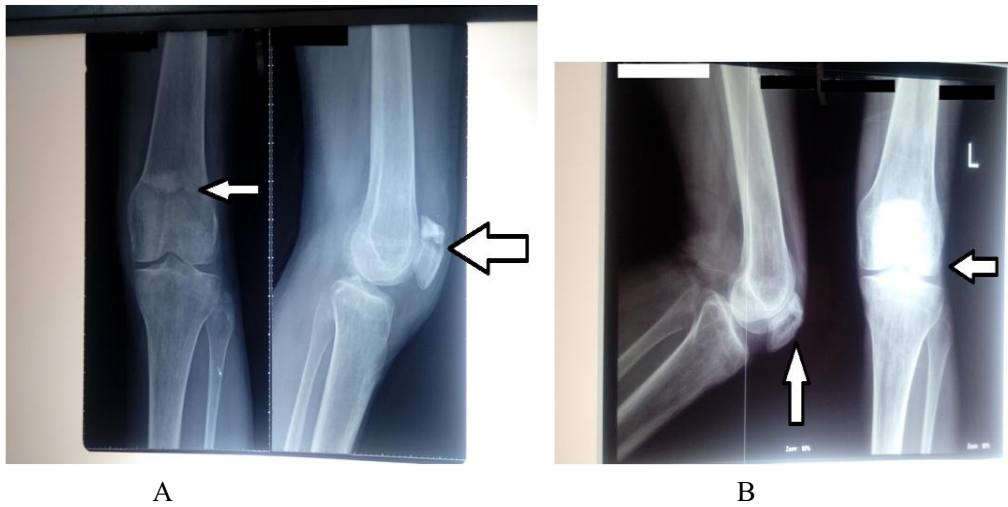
shows (A: x-ray of fracture of left patella before laser treatment and B: after the course of laser treatment)
